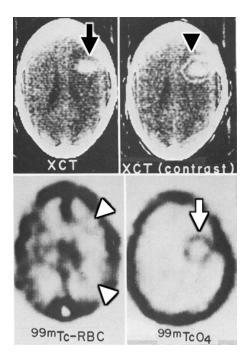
Intracerebral hematoma. 17-year-old with intraparenchymal hematoma (hematoma present for 2 weeks). Pre-contrast CT (XCT) demonstrates high attenuation hematoma (closed arrow) with surrounding "halo" of enhancement on postcontrast CT (XCT [contrast]) (closed arrowhead) secondary to hyperemia or altered blood brain barrier. Radiolabeled red blood cells (^{99m}Tc-RBC) demonstrate decreased ipsilateral cerebral blood volume (open arrowheads) and altered blood brain barrier surrounding the hematoma (^{99m}TcO₄) (open arrow). Published with permission granted by RSNA[®], originally published as Figure 9 in: Kuhl, DH, Edwards, RQ, Ricci, AR, et al. The mark IV system for radionuclide computed tomography of the brain. *Radiology*.
